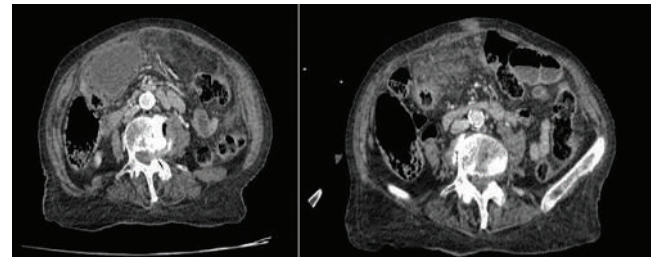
Preoperative CT images.
